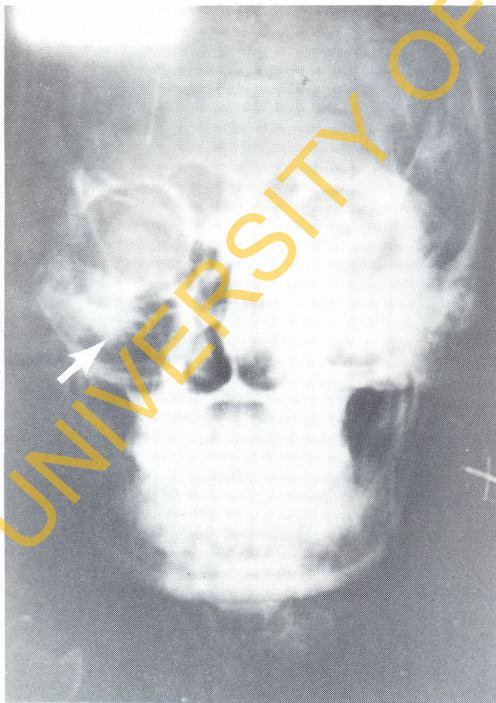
X-ray picture of a cap in the orbit.
